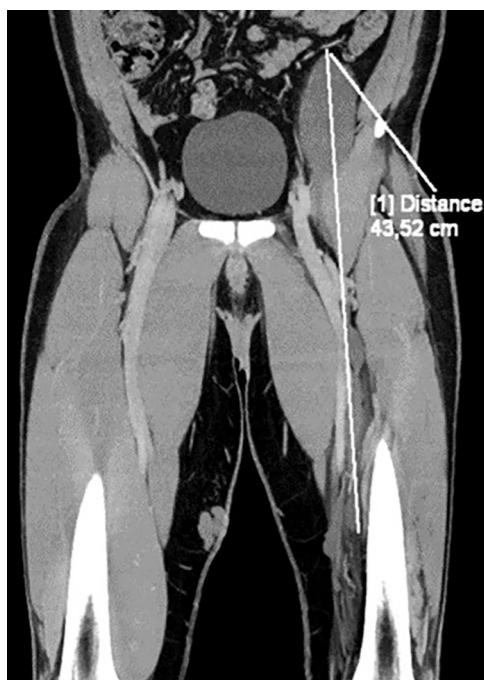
Contrast-enhanced CT oblique coronal MIP reconstruction showing polilobulated retroperitoneal mass spreading along common and superficial artery and vein to the level of the distal third of the left thigh (craniocaudal longest diameter 43,5 cm).
